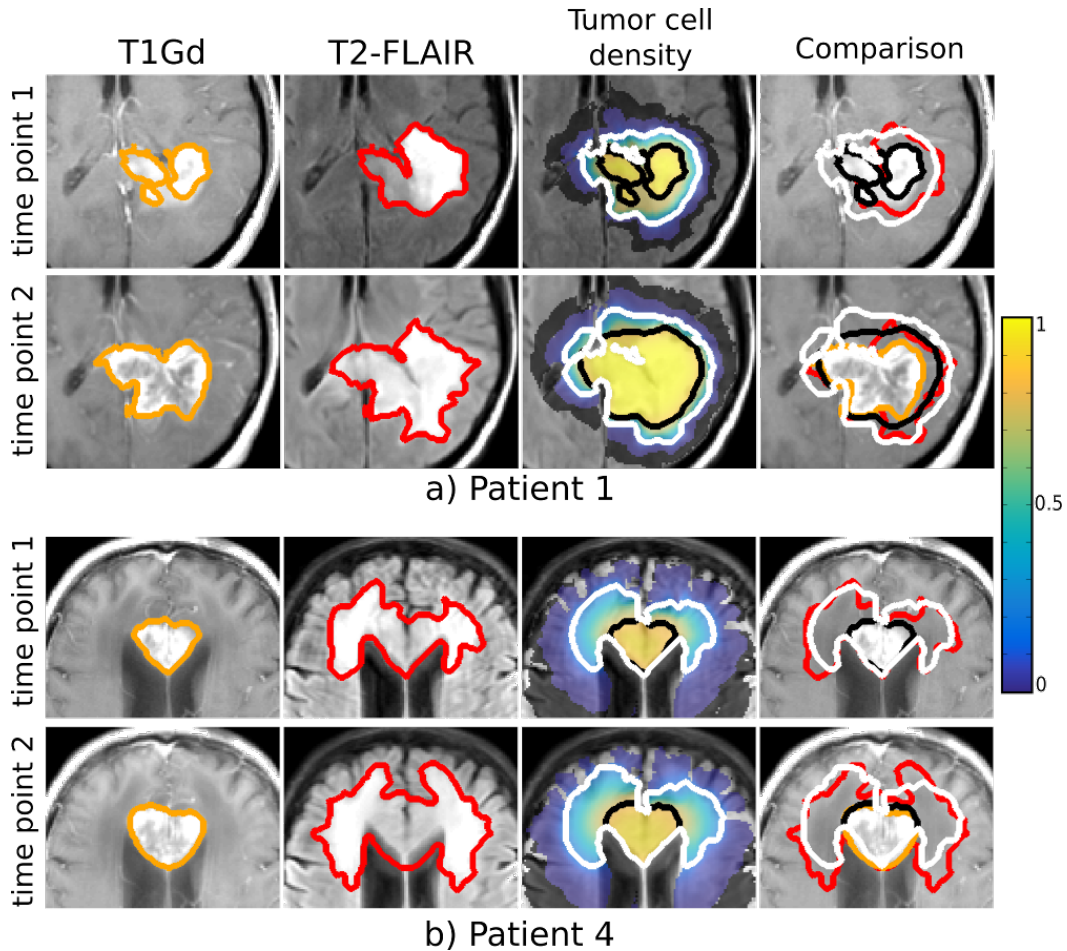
Maximum a Posteriori fit for Patient 1 (Top) and Patient 4 (Bottom). For each patient: (Left) The proliferative rim is outlined in orange on the T1Gd MRI at two different time points; (Middle Left) The edema is outlined in red on the T2-FLAIR MRI at two different time points; (Middle Right) Tumor cell density, the black (resp. white) line is the threshold value τ_1 (resp. τ_2) corresponding to the T1Gd (resp. T2-FLAIR) abnormality; (Right) Comparison between the clinician segmentation and the contours from the model.
